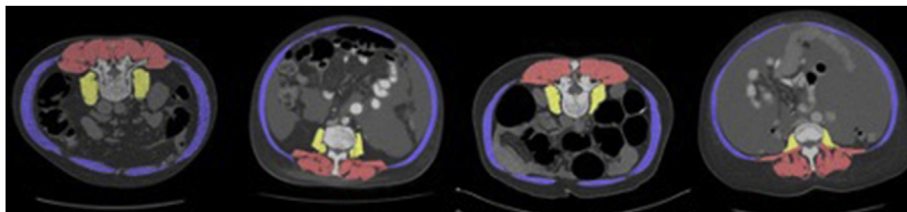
Examples of CT sections with manual segmentations of the muscle into erector spinae, psoas, and rectus abdominus. The colon dataset contained a mix of prone and supine patients.
